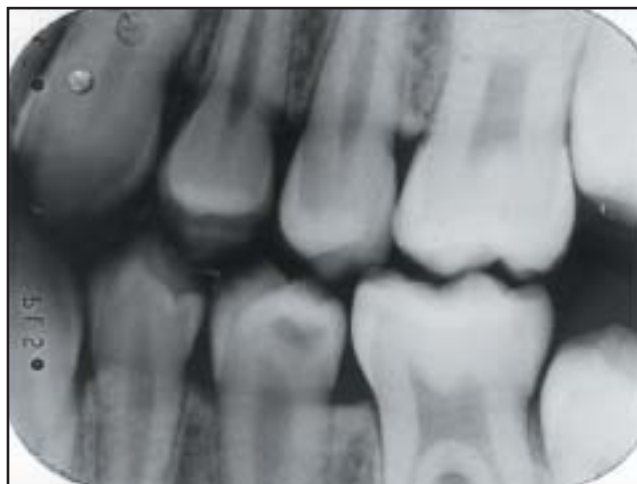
Bitewing radiograph taken six months after placement of fissure sealant on left mandibular second premolar. Note large radiolucent lesion in the dentin in the distal coronal portion of the tooth under intact enamel structure. The pulp horn is slightly recessed under the lesion.
